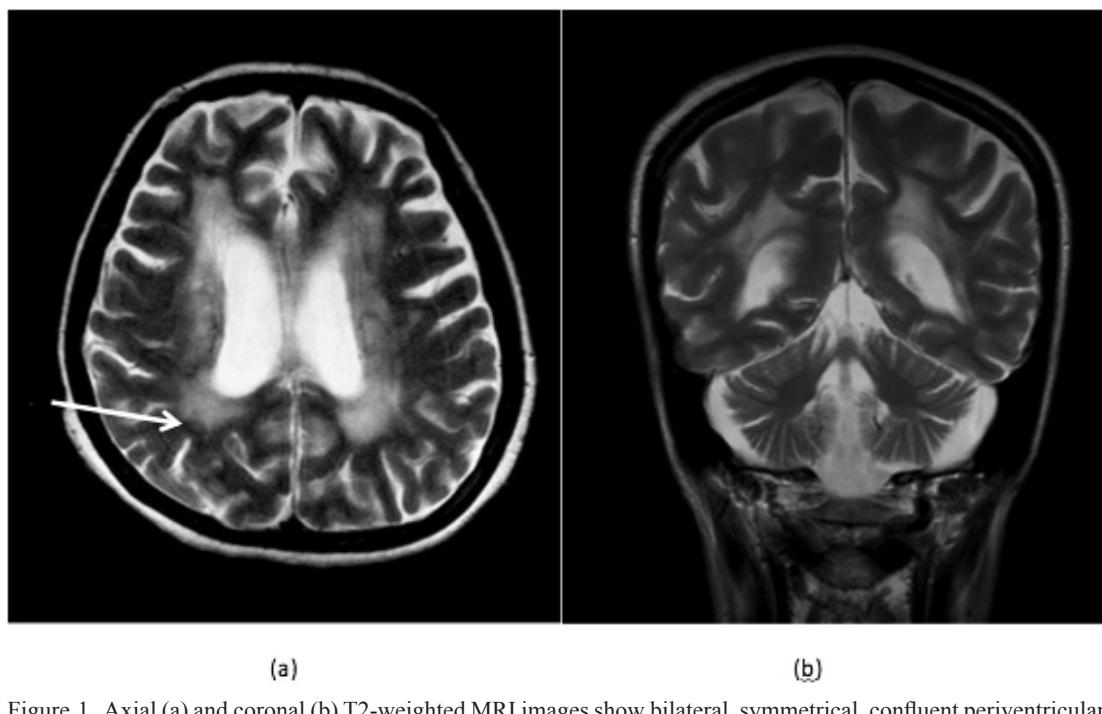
Axial (a) and coronal (b) T2-weighted MRI images show bilateral, symmetrical, confluent periventricular and deep white matter change with relative sparing of the subcortical U fibers (arrow).
